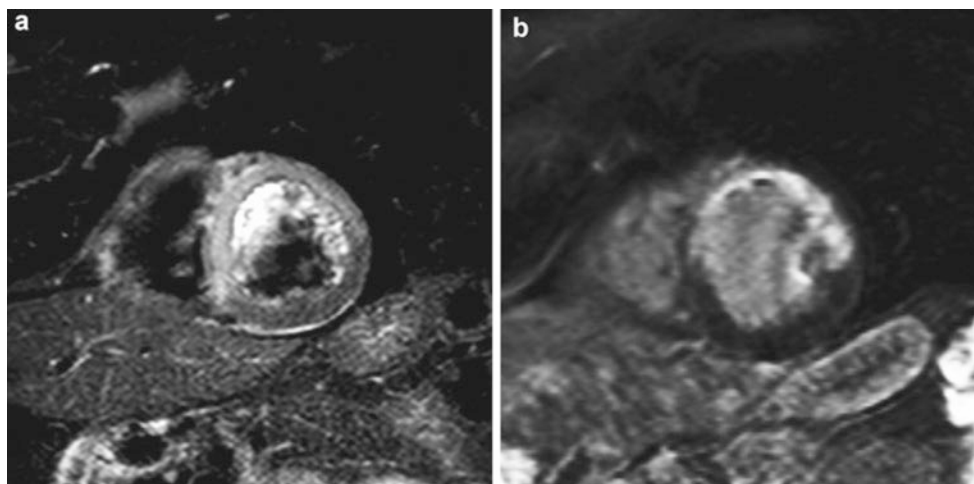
T2-weighted CMR performed early after successful MI reperfusion is useful to retrospectively quantify the myocardium at risk and the salvaged myocardium. This example shows a T2-weighted image (a) and delayed enhancement (DE)-CMR image (b) from a 77-year-old man with an extensive anteroseptal acute MI. On short-axis
